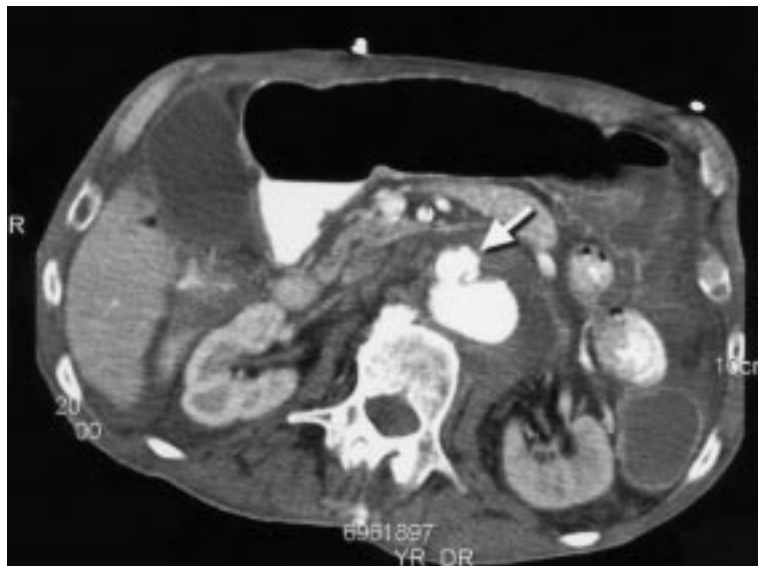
Computed tomographic scan showing saccular aneurysmal dilatation at the anterior aspect of the abdominal aorta (arrow) with low attenuation surrounding the lumen.
